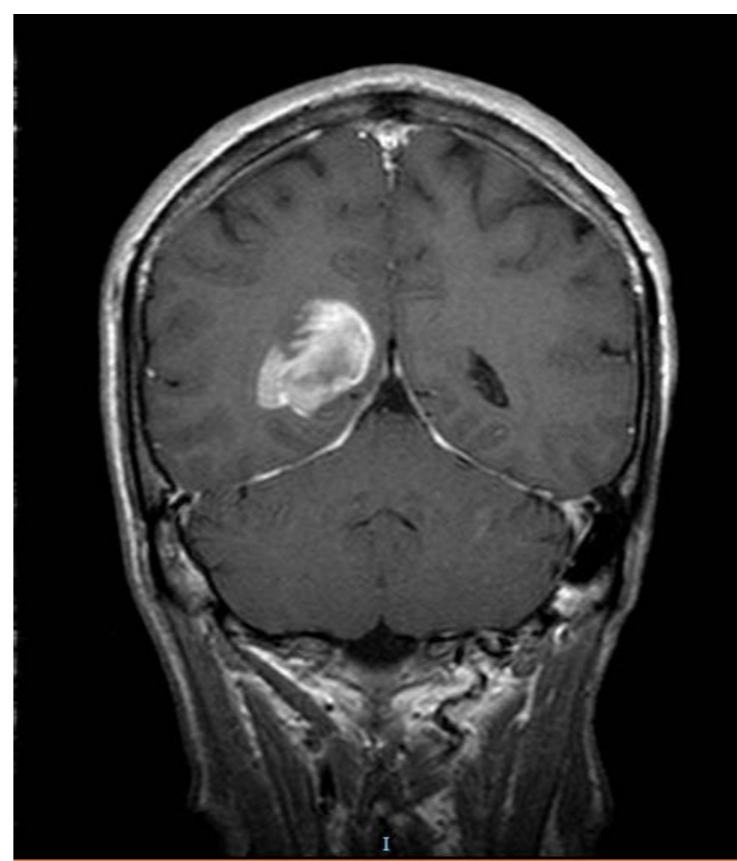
MRI T1 GD, coronal scan
